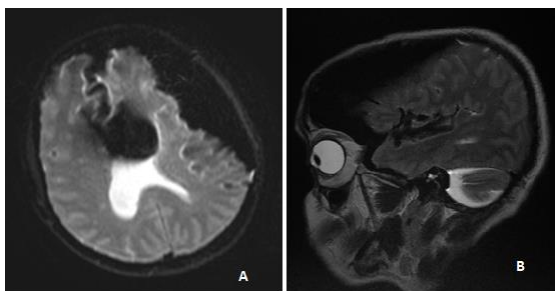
MRI Brain revealed air in the left subdural space along left fronto-parieto-temporal convexity with mass effect and midline shift suggestive of tension pneumocephalus.
